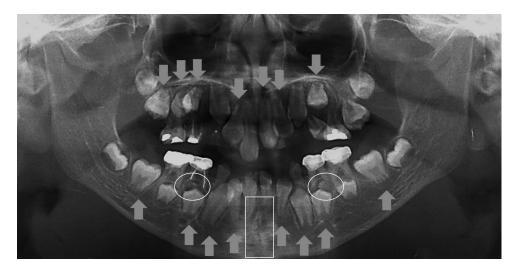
Orthopantomogram of case 7 (10 years 5 months). Delayed fusion of the mandibular symphysis is shown (white rectangle). There are two supernumerary teeth in the premolar region of the mandible (dotted circle). A total of 15 impaction or delayed eruption of permanent teeth were observed (gray arrow).
